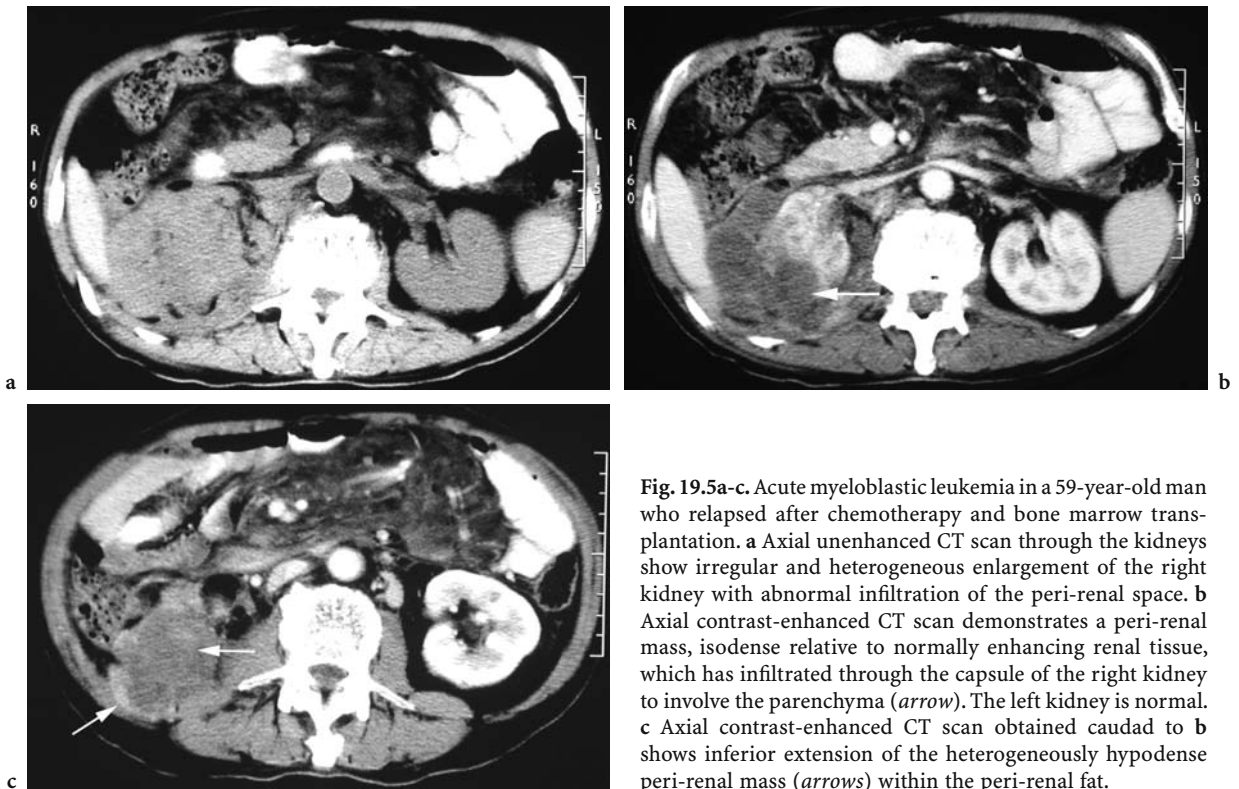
Acute myeloblastic leukemia in a 59-year-old man who relapsed after chemotherapy and bone marrow transplantation. a Axial unenhanced CT scan through the kidneys show irregular and heterogeneous enlargement of the right kidney with abnormal infiltration of the peri-renal space. b Axial contrast-enhanced CT scan demonstrates a peri-renal mass, isodense relative to normally enhancing renal tissue, which has infiltrated through the capsule of the right kidney to involve the parenchyma (*arrow*). The left kidney is normal. c Axial contrast-enhanced CT scan obtained caudad to b shows inferior extension of the heterogeneously hypodense peri-renal mass (*arrows*) within the peri-renal fat.
